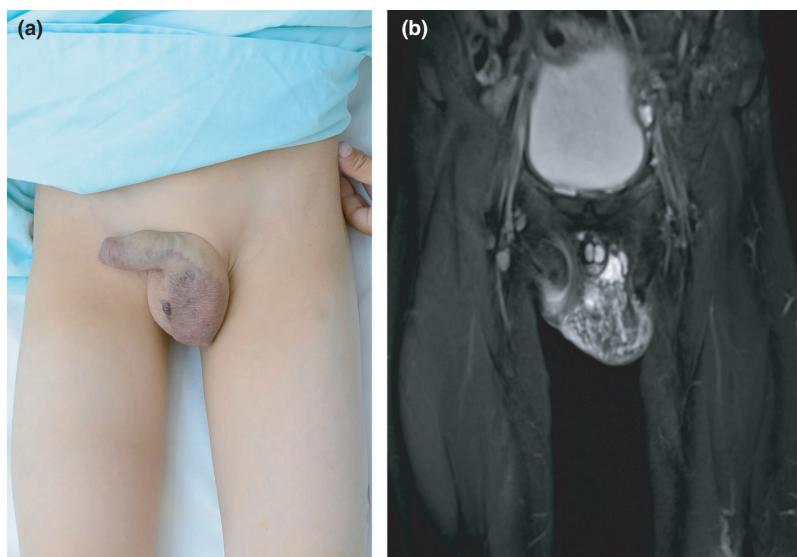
(a, b) Patient with capillary–venous–lymphatic malformation: (a) clinical image of the pelvis and thighs. (b) contrast-enhanced T1-weighted magnetic resonance image of the same area (coronal view), showing venous portions in scrotum and penis with prostate and seminal vesicle involvement, and capillary portions at the skin level of the scrotum and penis.
